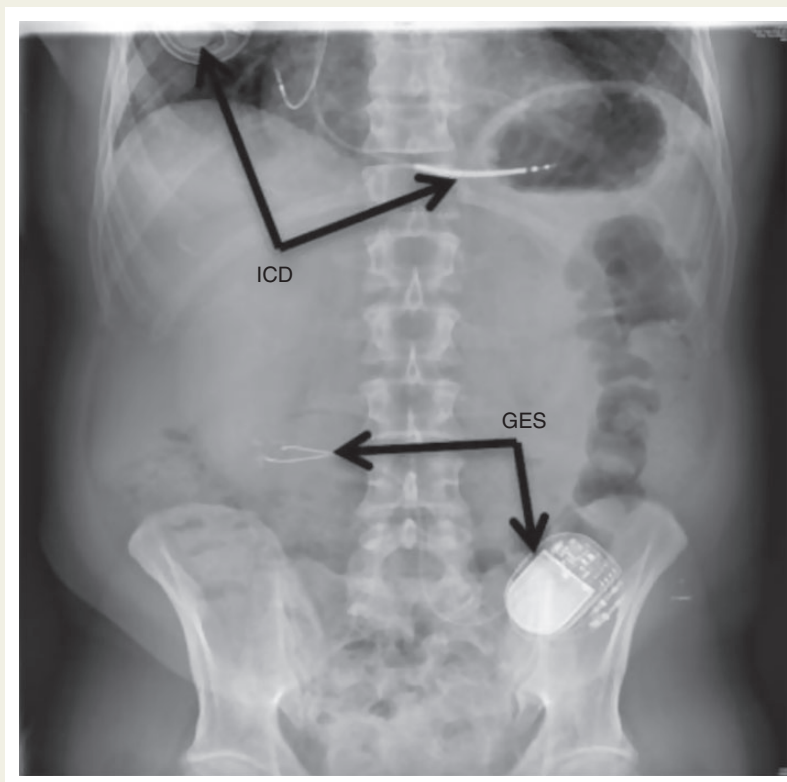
X-Ray of a dual-IED therapy. GES, device for gastric electrical stimulation; ICD, implantable cardioverter defibrillator leads.
